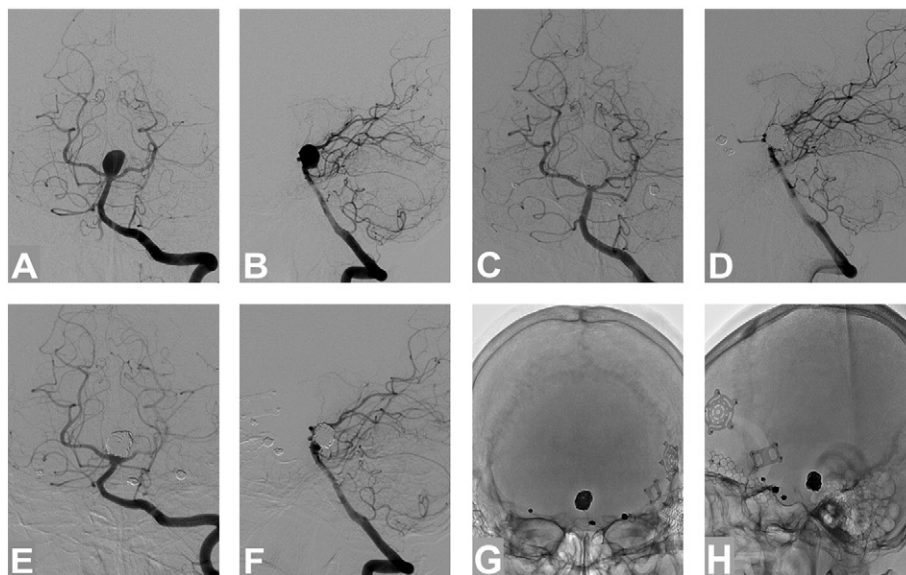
Double-microcatheter technique. Unruptured basilar-tip aneurysm case of 41-year-old female. Aneurysm size is 10 mm, neck 5.2 mm, and DNR = 1.94. Panels A and B show the pre-embolization imaging on catheter angiography. Panels C and D show the initial occlusion. Panels E and F show the angiographic follow-up at 100 months. Panels G and H show the skull x-ray follow-up at 120 months, which demonstrates stable and solid coil mass structure.
